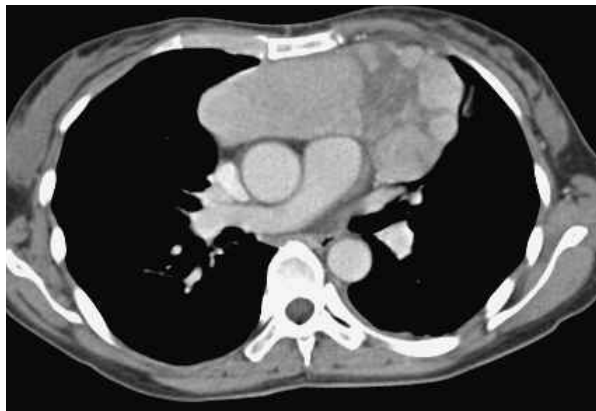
Chest CT scans showed a mediastinal mass.
